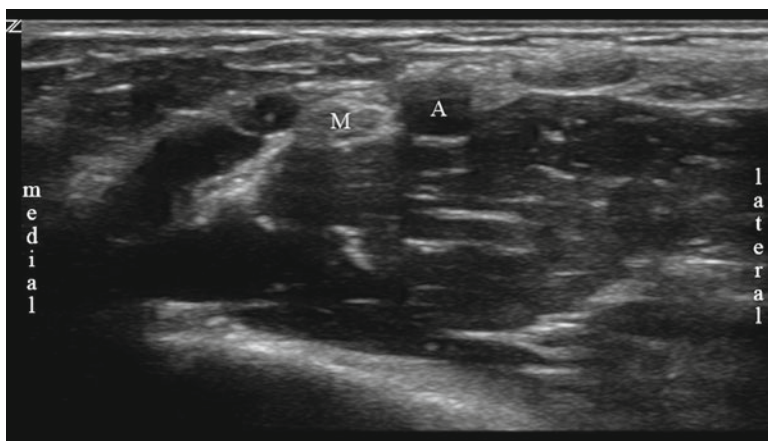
Ultrasonographic appearance of the median nerve at the elbow (A brachial artery, M median nerve)
